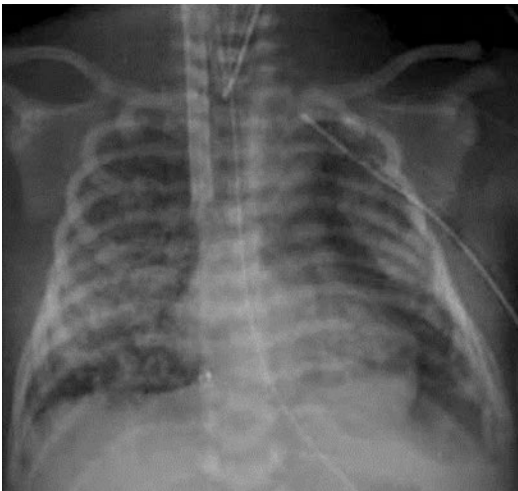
Meconium aspiration syndrome. Chest X-ray of a term newborn combines alveolar interstitial shadows with slightly collapsed areas with pneumothorax to the left side, partially leaking with the insertion of a chest tube. Patient is intubated and connected to venoarterial extracorporeal membrane oxygenation (ECMO)
